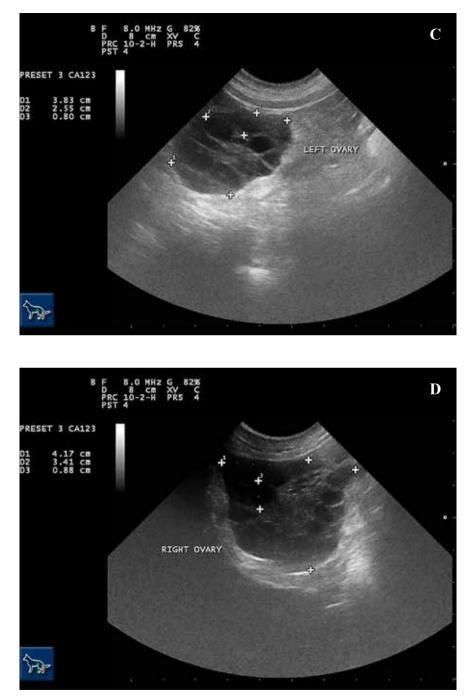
Ultrasonography of the Shar Pei's ovaries during recombinant human chorionic gonadotropin treatment. Sagittal view of both ovaries, performed by MyLab[™] 40 VET, Esaote S.p.A., Genova, Italy. C and D show ovaries on day 23 after insemination.
